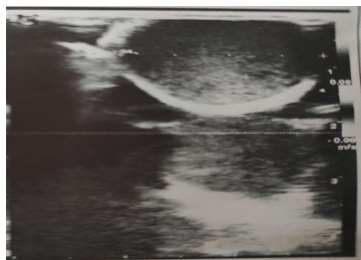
There was a well-defined, oval, hypoechoic cystic lesion in left ear lobule, subcutaneous tissue plane with low level internal echoes and posterior acoustic enhancement. The lesion was thin walled without internal color doppler flow. No communicating tracts seen. Perilesional tissue was normal. Features were suggestive of epidermoid cyst.
